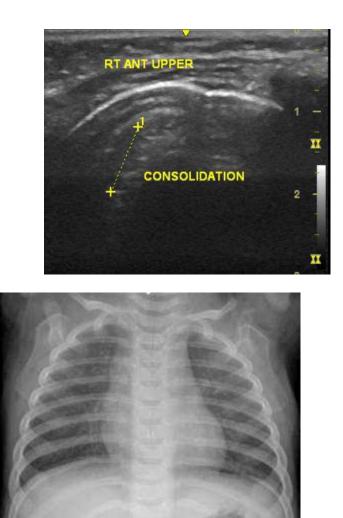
Transverse Thoracic Ultrasound Scan showing an irregular subpleural Consolidation measuring 0.86cm. Chest X-Ray of the same patient was normal
